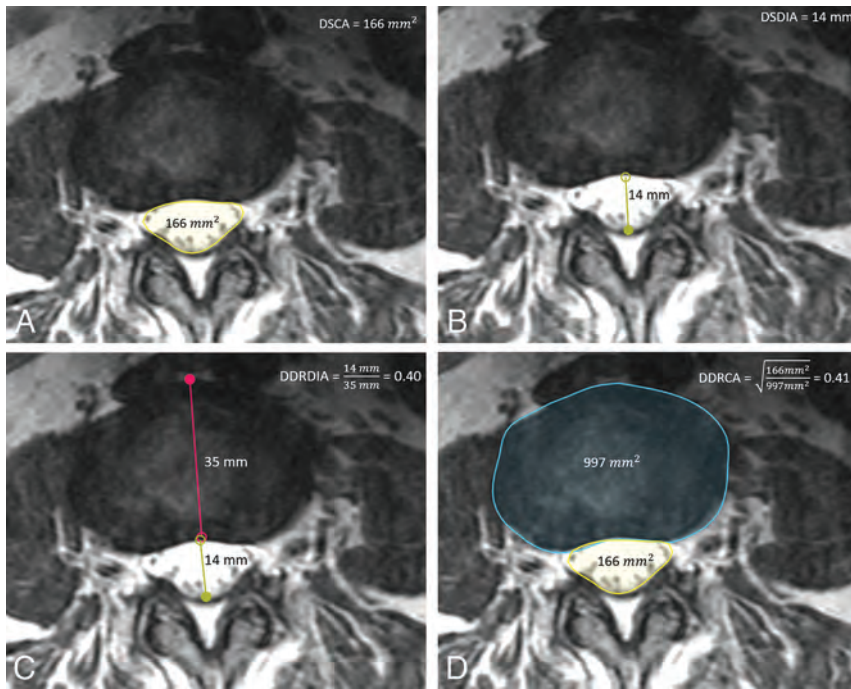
Sample T2-weighted axial section at L2/L3 graded normal with the following: A, Free-form annotation around the DSCA of 166 mm². B, Line annotation with a DSDIA of 14 mm. C, Line annotations with a DDRDIA of 0.4. D, Free-form annotations with DDRCA of 0.41. The square root is used as a normalization step to account for the quadraticity of area measures.
